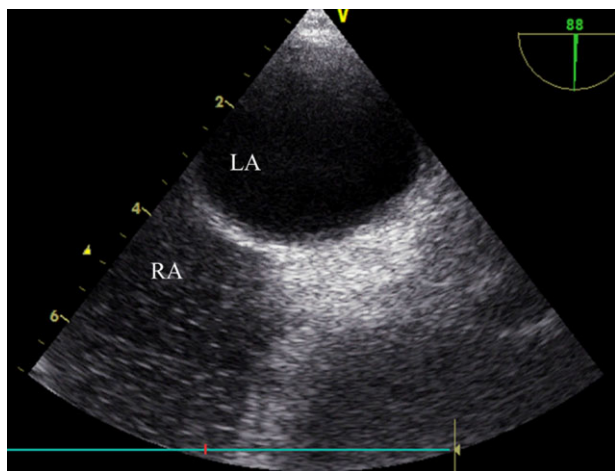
Image from the transesophageal echocardiographic study conducted on the 54th hospital day. Transesophageal echocardiography was performed in the prone and sitting positions. Microbubble opacification after intravenously administered normal saline was not detected in the left atrium after either two or six cycles. LA, left atrium; RA, right atrium.
